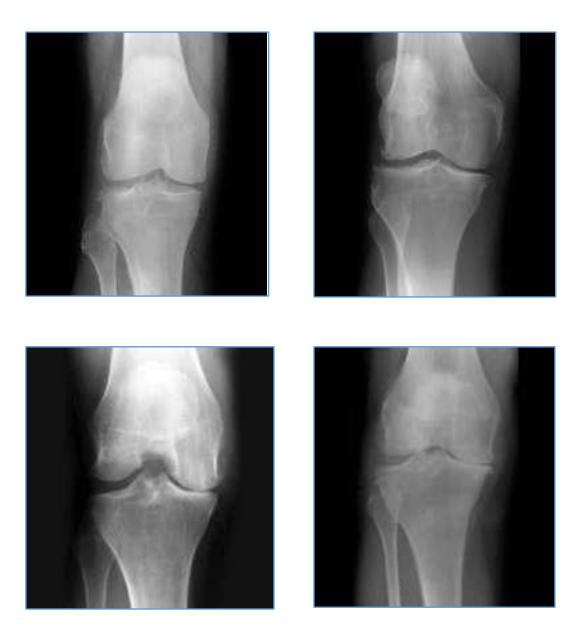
Radiograph of OA Knee.
